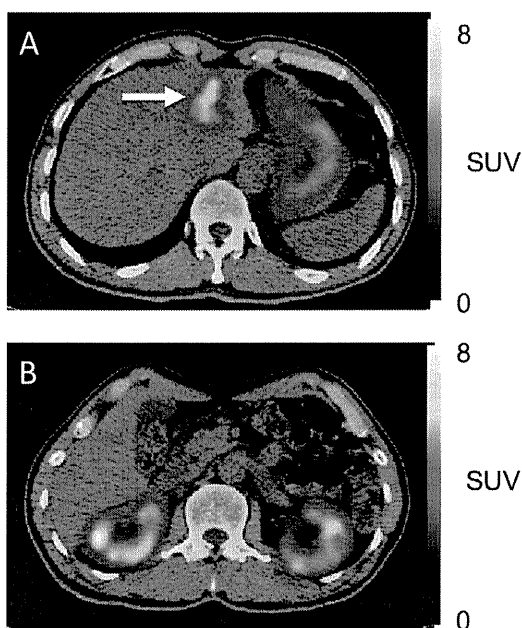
Combined positron emission tomography (PET)/computed tomography (CT) scans showed accumulation of ^{18}F -fluorodeoxyglucose (FDG) in a liver lesion (A) and the kidney lesions (B). More marked FDG uptake was shown in the affected areas of the kidney lesions consistent with the multiple low-density lesions detected by CT. An arrow indicates the abnormal region in the liver.
